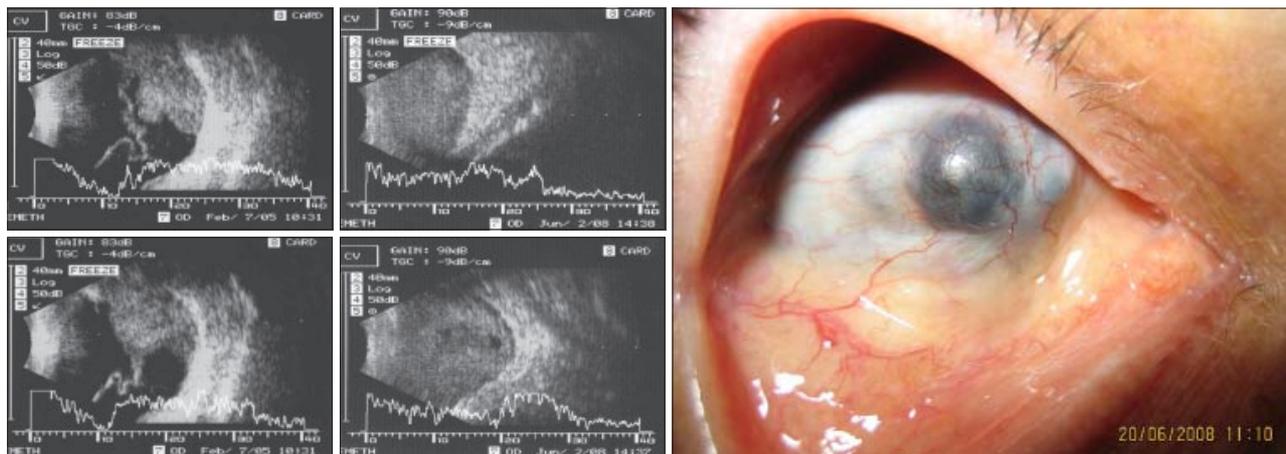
a) Ultrasound A, B modes in 2005 before enucleation, b) Ultrasound of the orbit in A, B modes in 2008, c) Clinical findings of the patient with tumor mass in the orbit three years after enucleation.
